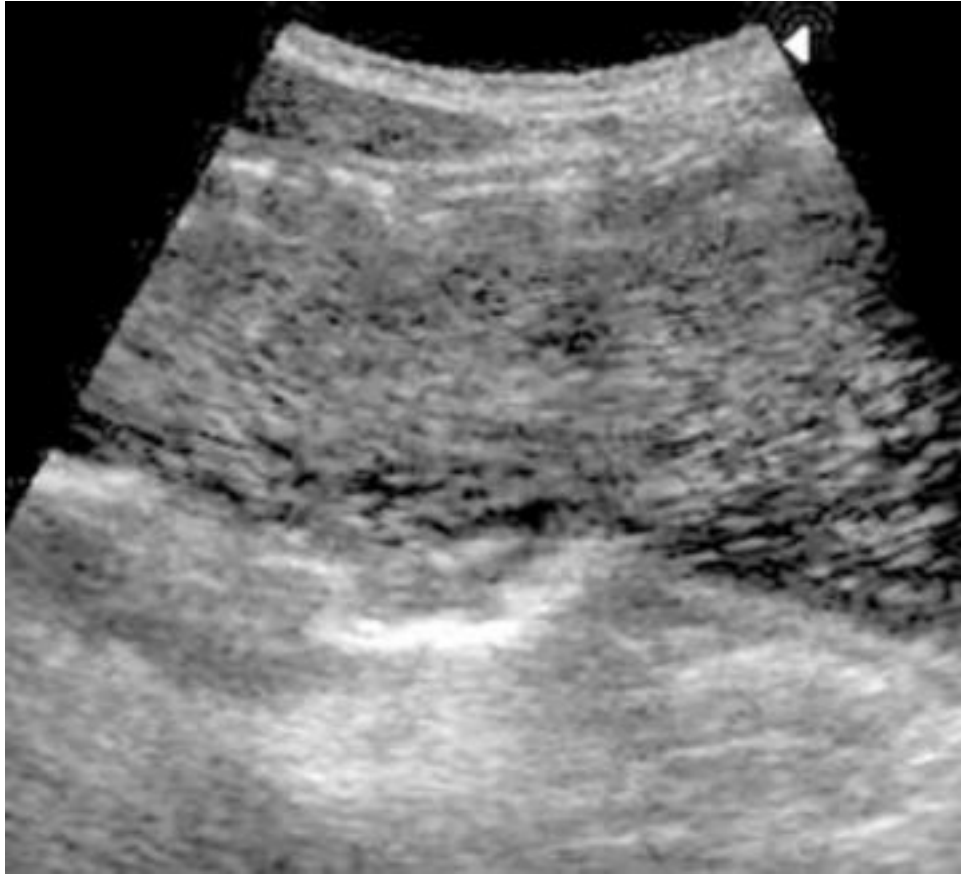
Ultrasound of the abdominal organs
